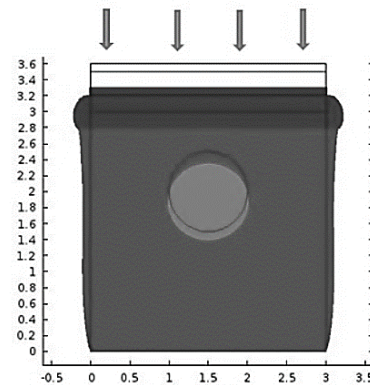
Ultrasound probe is pressed at the top surface which is represented by fixed displacement of 0.03 cm
